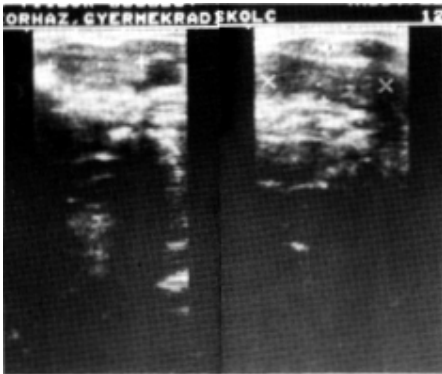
Three months after normal sized thyroid gland (right and left lobe) was found by ultrasound.
